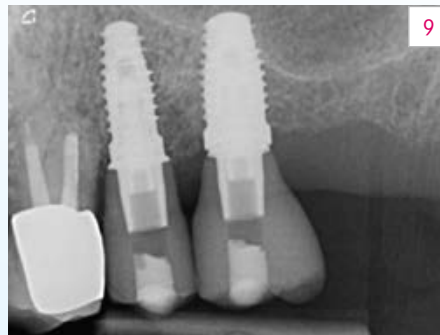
Control x-ray image following integration of the restorations.
